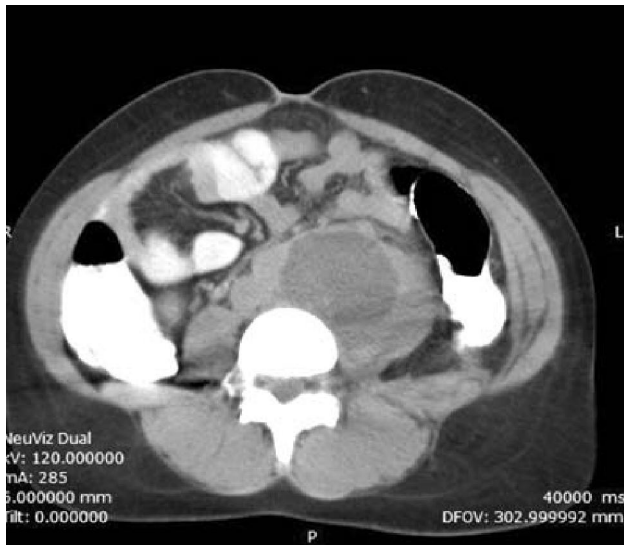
The patient's CT scan image showing enlarged left iliopsoas muscle with a hypodense lesion within it and some surrounding fatty stranding.
